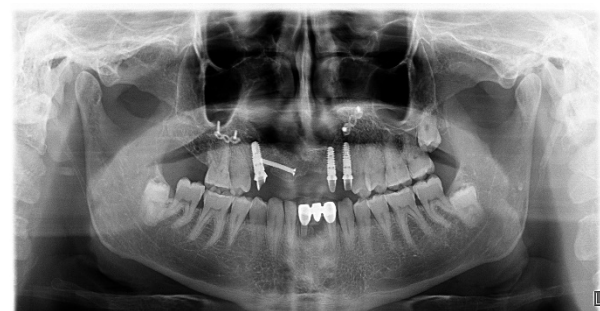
Panoramic radiograph of the patient in 32th month of the surgery. (21 months after prosthetic load)
